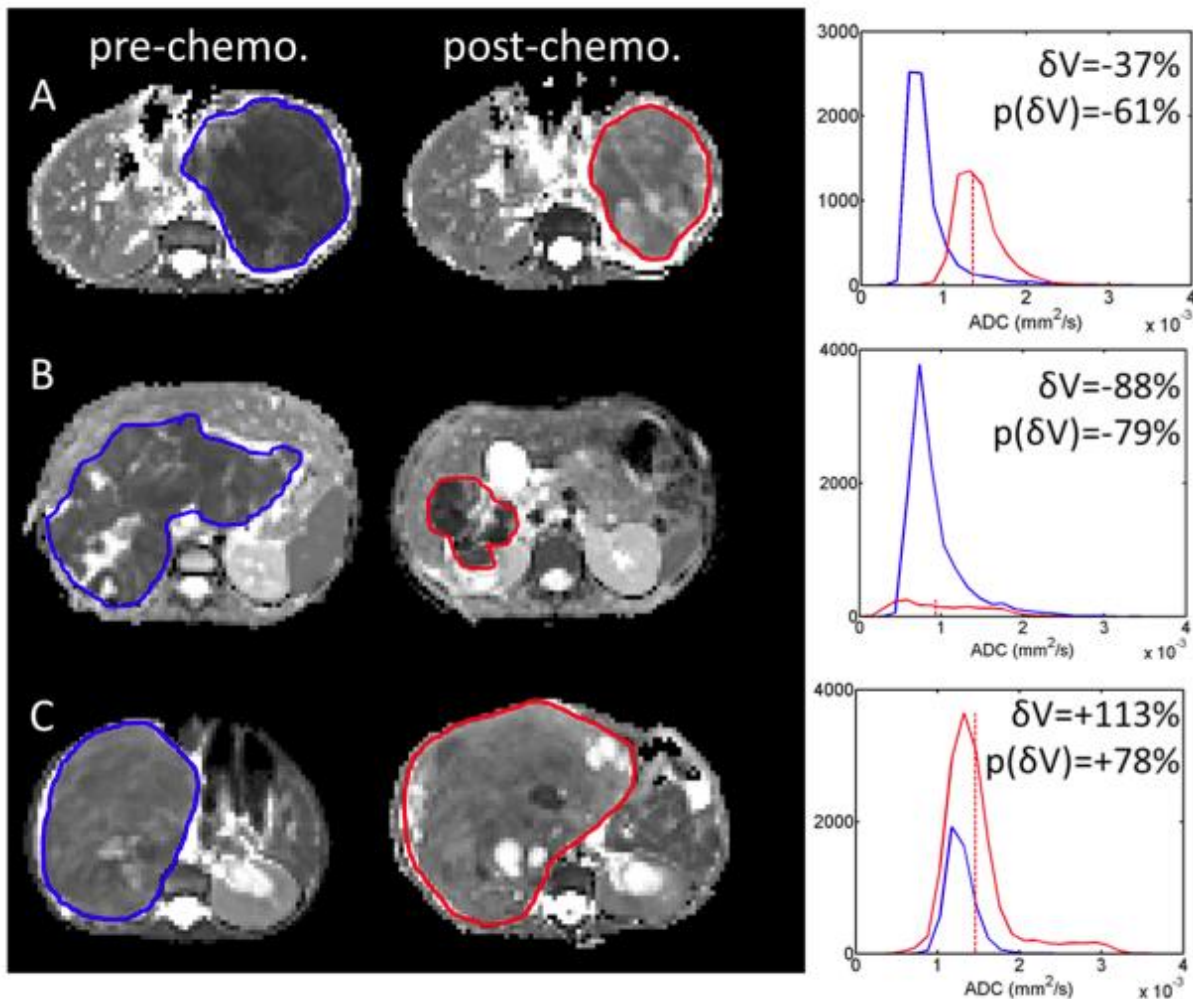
DWI and ADC mapping of nephroblastoma from different patients before and after pre-operative chemotherapy. Presented at the annual meeting of the British Chapter of the ISMRM, September 2012, provided by Prof. Kathy Pritchard-Jones from UCL.
